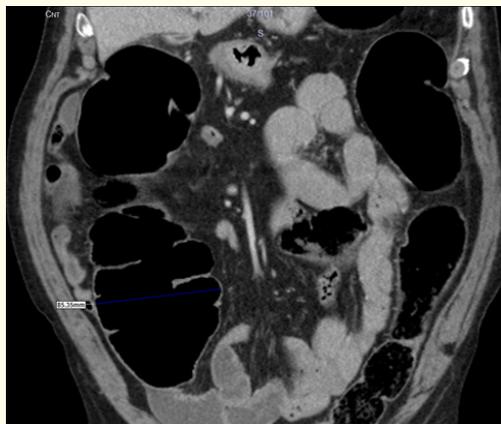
The colonic tumor suspicion in abdominal contrast-enhanced computed tomography.
